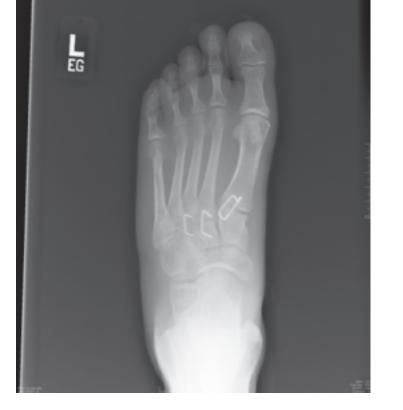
Anterior-posterior (AP) radiograph of a foot demonstrating staple fixation of the Lisfranc joint.
